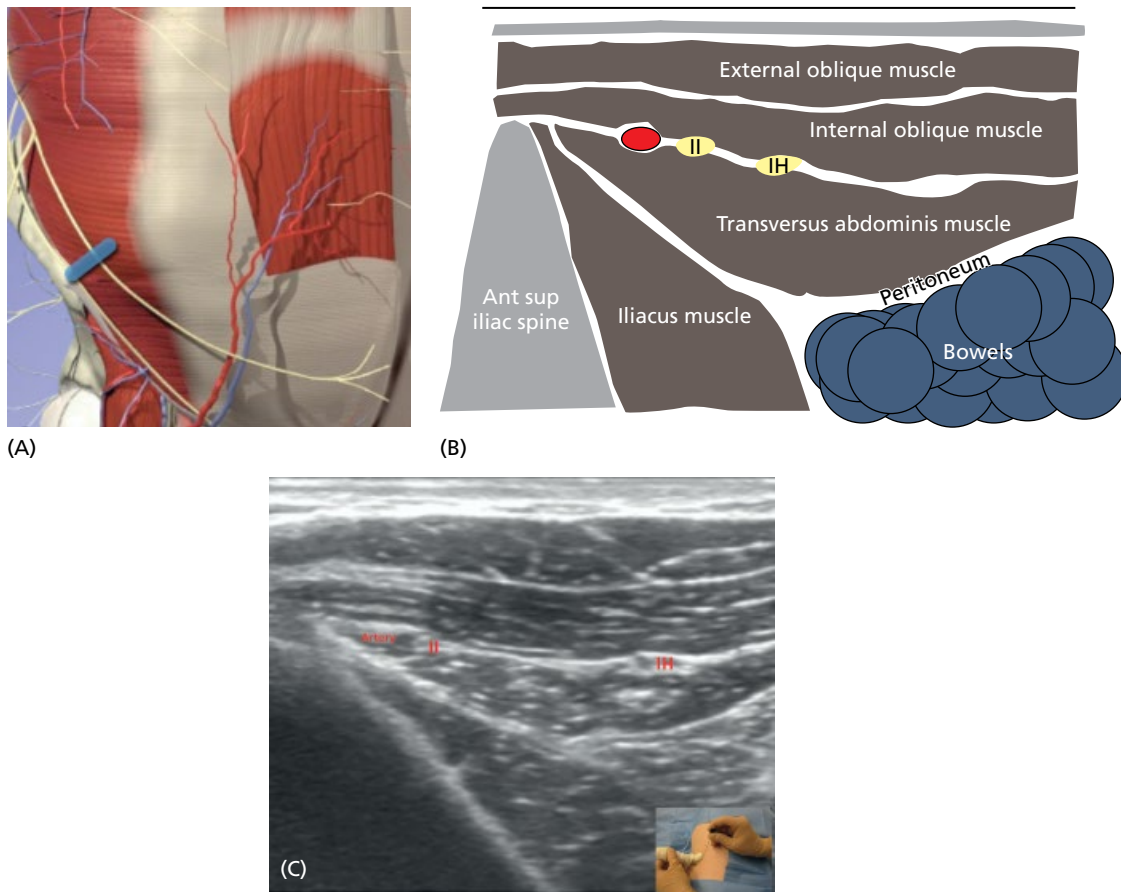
The abdominal region. (A) Anatomy. (B) Ultrasound imaging. After placement of a linear or hockeystick ultrasound probe along the anterior superior iliac spine with the probe oriented toward the umbilicus, the three layers of the abdominal wall muscles can be recognized. The ilioinguinal nerve and iliohypogastric nerves are seen as two hypoechoic structures between the internal oblique and transversus abdominis muscles. (C) Ultrasound image. II, ilioinguinal nerve; IH, iliohypogastric nerve. See text for further details.
